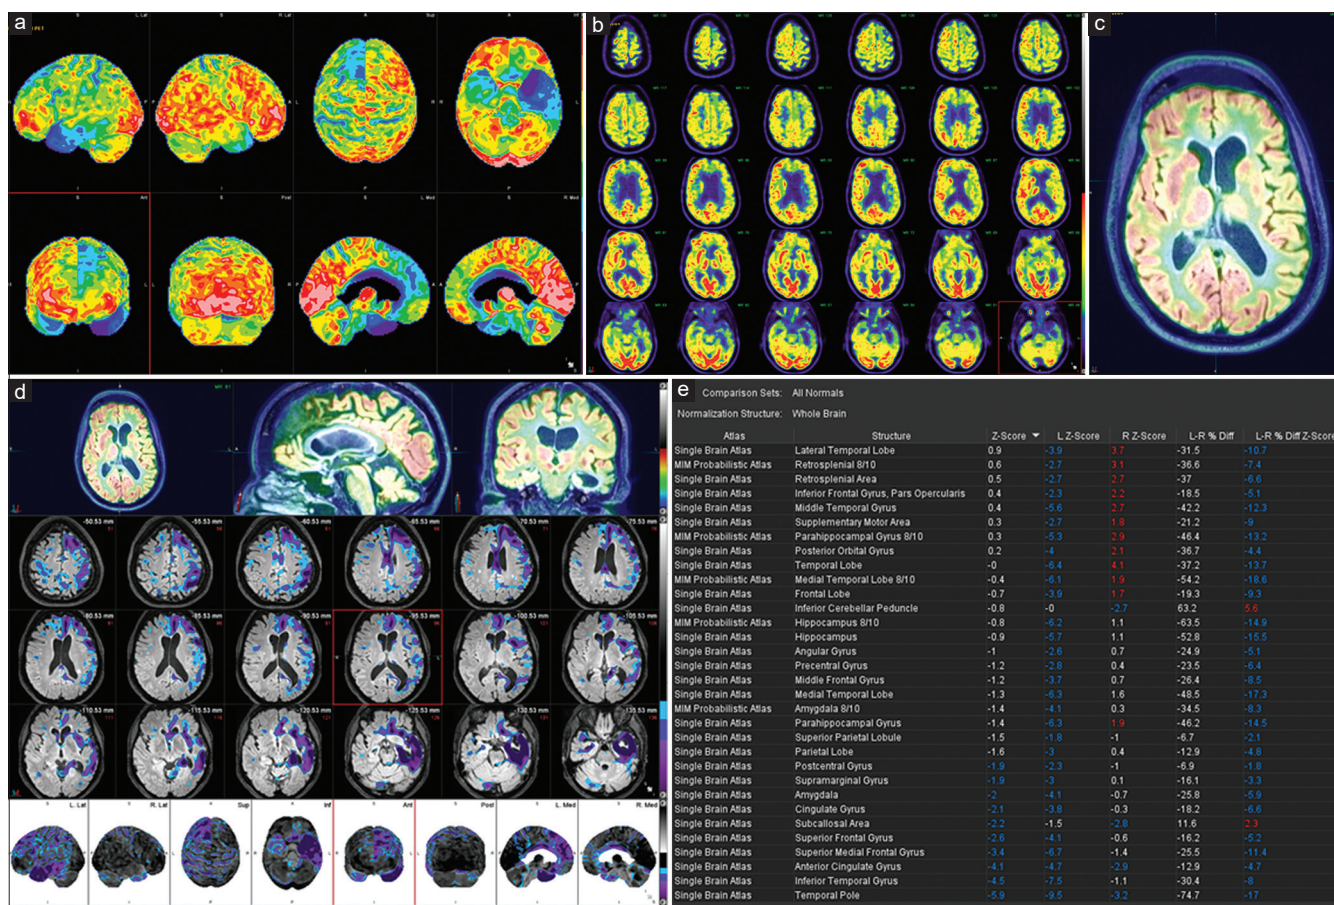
(a) Cortical fluorodeoxyglucose-positron emission tomography surface maps. (b) Transaxial fusion images (axial fluid-attenuated inversion recovery and positron emission tomography). (c) Select fusion fluid-attenuated inversion recovery/positron emission tomography axial image through the subcortical structures. (d) Fluid-attenuated inversion recovery-magnetic resonance imaging and positron emission tomography images with semi-quantitative Z-score overlays. (e) MIMneuro Z-score fluorodeoxyglucose brain data in tabular format
